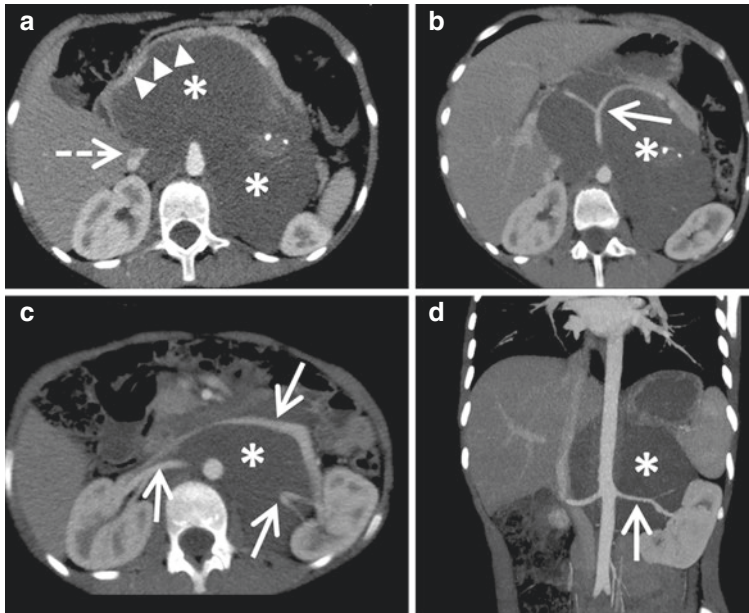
A 9-month-old girl with localized left adrenal intermixed ganglioneuroblastoma (asterisks). Contrast-enhanced CT scan with transverse views (a, b) and axial (c) and coronal (d) MIP reconstructions. IDRfS are present (arrows): encasement of the aorta, the celiac, hepatic and splenic arteries, both renal arteries, and the left renal vein. The tumor is in contact with the IVC (dotted arrow), but its lumen is still visible (not IDRf). The duodeno-pancreatic bloc is invaded (arrowheads) (IDRF)
